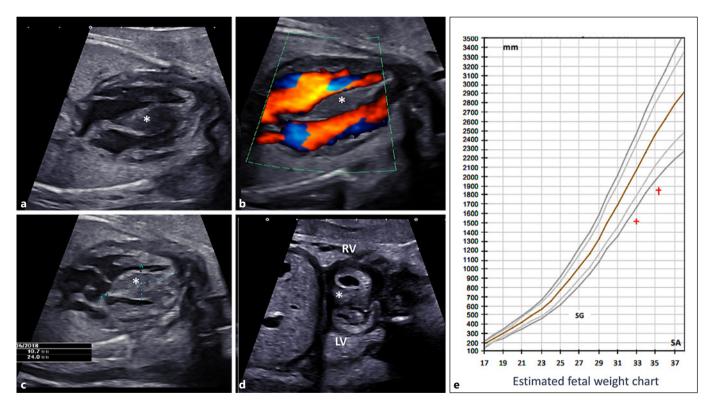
Patient referred at 33 weeks of gestation (WG) for severe intrauterine growth restriction (IUGR). Examination of the fetal heart. On the axial 4-chamber views of the heart with 2D standard ultrasound (a) and using the color Doppler ultrasound (b), severe septal hypertrophy (*) 10.7×24 mm on the axial view (c) and 8.7
